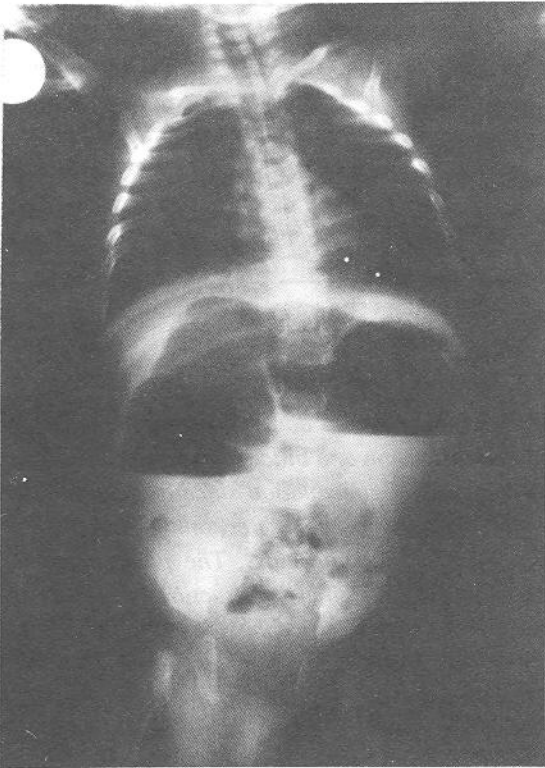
Plain abdominal x-ray with massive large dilatation of transvers colon.
